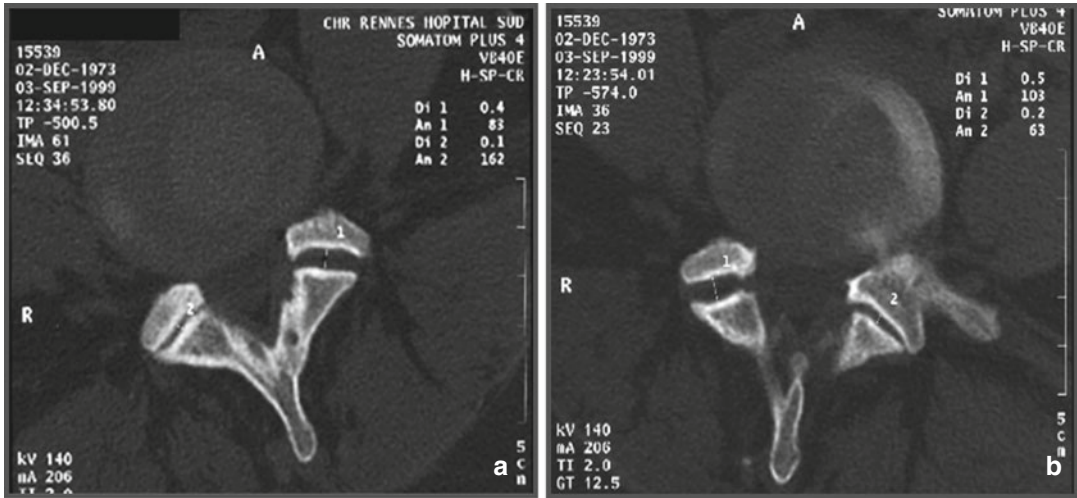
Twist CT scan at 24 months postoperative for patient no. 1; facet joints appear to function normally
